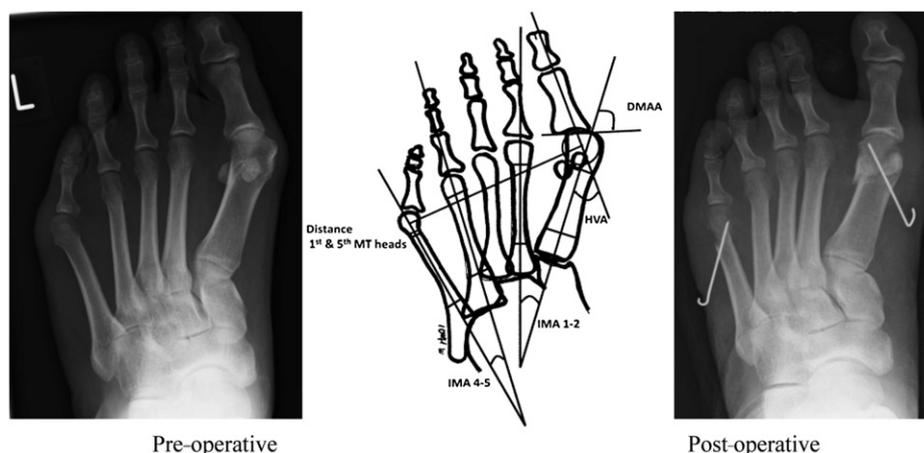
The pre and post-operative radiographs of the foot and the measurements. DMAA = distal metatarsal angle; HVA = hallux valgus angle; IMA = intermetatarsal angle; MT = metatarsal.
